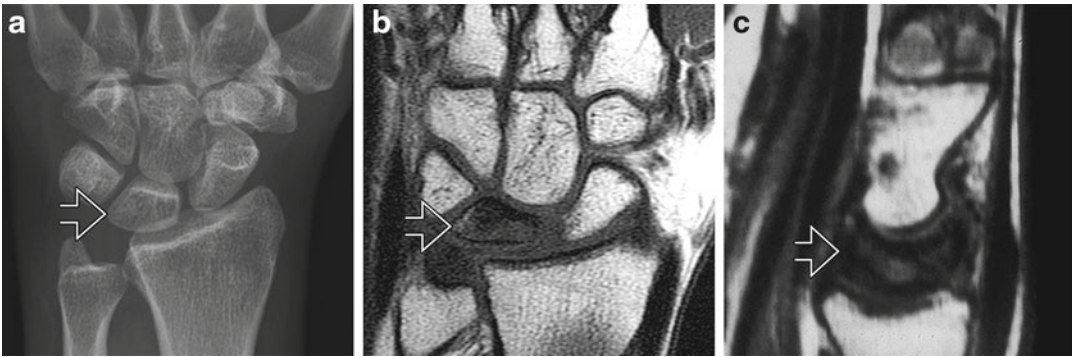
Stage I Kienböck's disease. (a) Radiograph shows normal appearance of the lunate (*arrow*). There is an ulnar-negative variance. Coronal (b) and sagittal (c)
